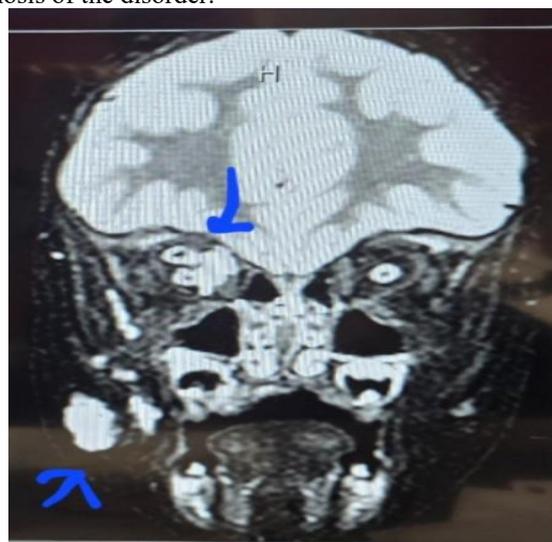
In this image you can see the right orbital Venolymphatic Malformation as well as the one in the right cheek region, both highlighted with contrast during the MRI study. This was pre sclerotherapy.
